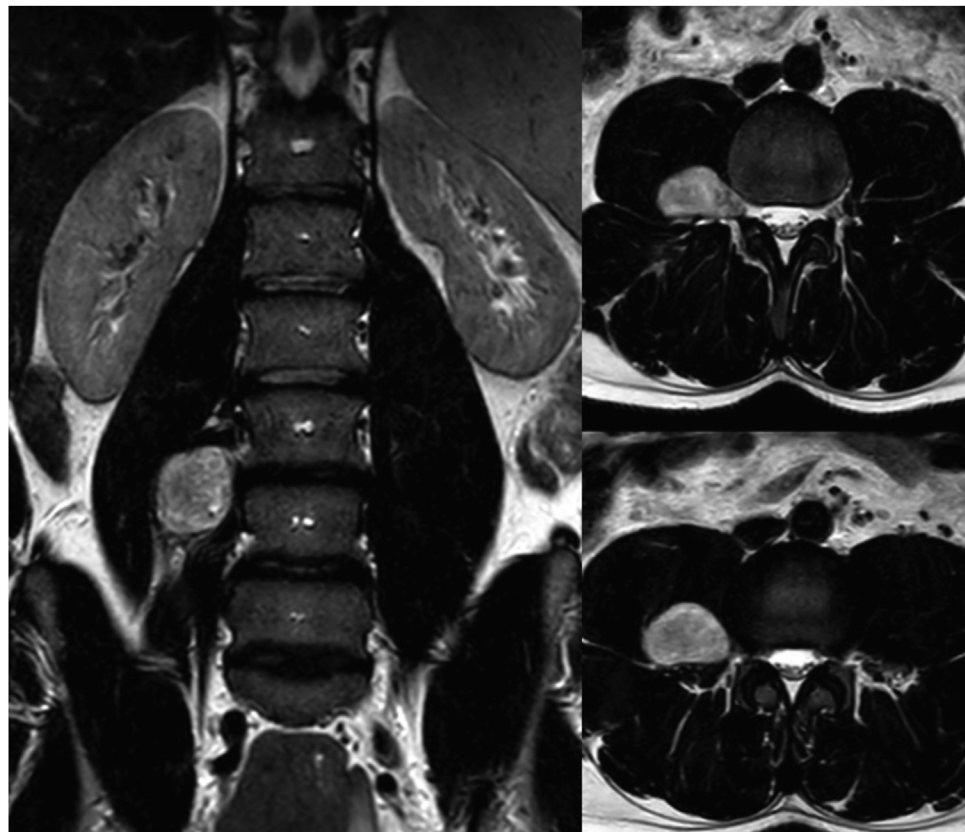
Preoperative contrast-enhanced MRI imaging showing right L3–L4 intra-extraforaminal schwannoma. MRI, magnetic resonance imaging.
